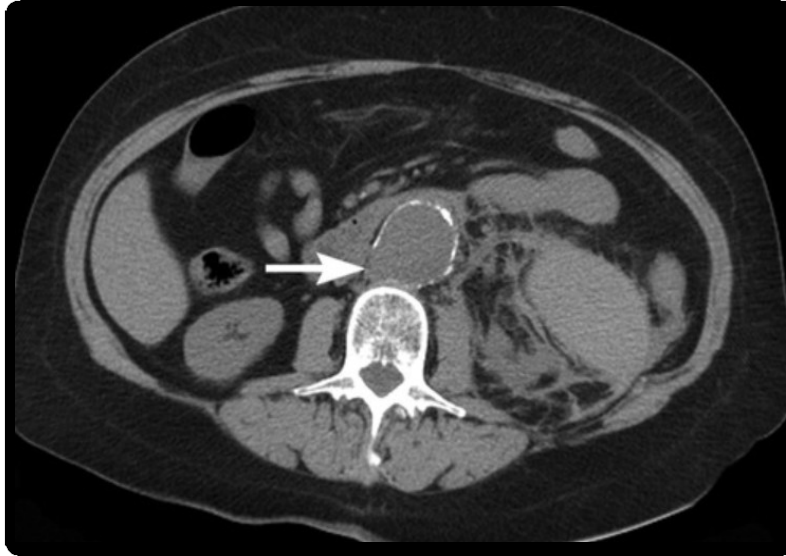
Unenhanced axial CT showing discontinuity of aortic wall calcifications (white arrow).
